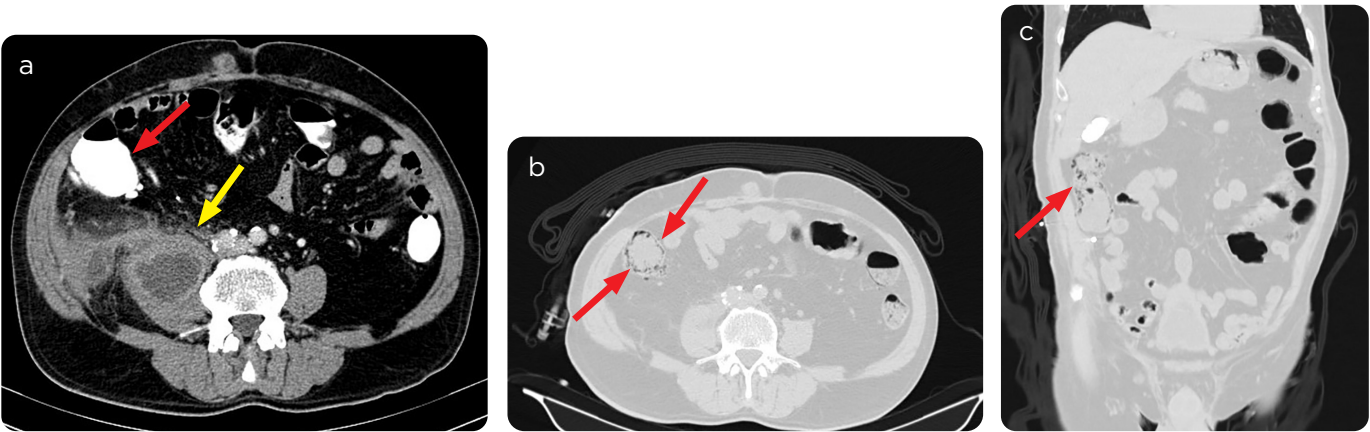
71-year-old patient with sensation of mass in right iliac fossa. a): Abdominal CT scan on admission with collection in right iliac psoas muscle (yellow arrow), without evidence of pneumatosis in the neighboring colon (red arrow). b and c) Control CT scan after colonoscopy: it rules out masses in the colon and shows cystic images, of low density (arrows) in the mucosa of the ascending colon due to cystoid pneumatosis.
